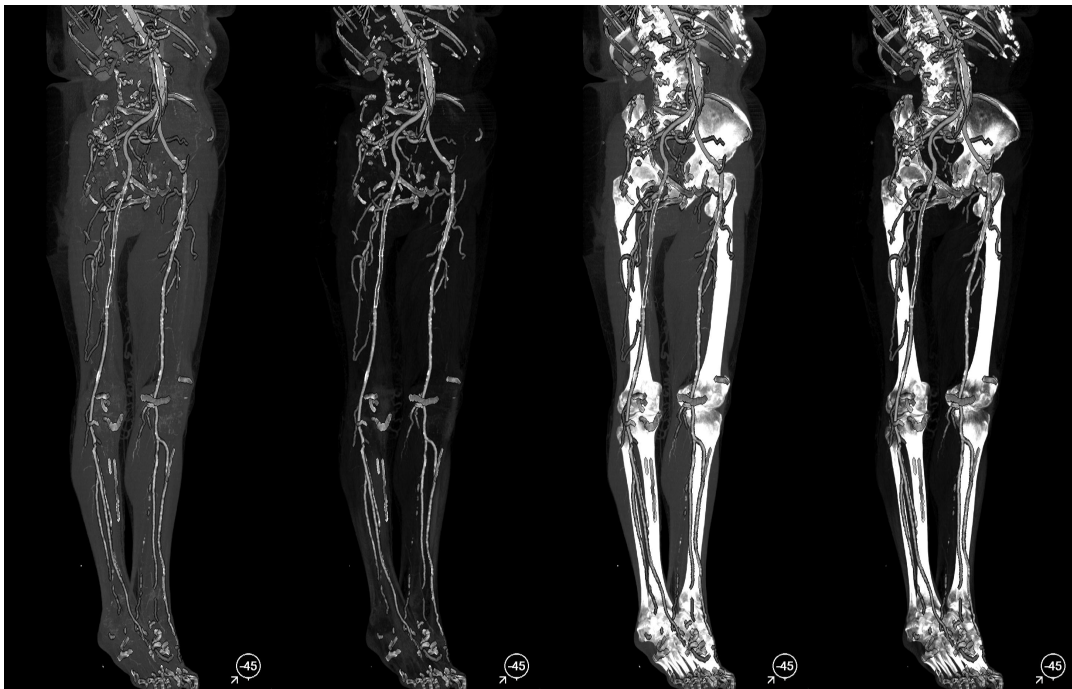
Result of focus and context rendering of a human CTA data-set. In all images the whole detected vessel tree is rendered. In the first two images bone is removed. Furthermore, the first and the third image use MIP whereas the second and the fourth image use MIDA. It is noteworthy that those contexts were rendered utilizing the described polygon rasterization, because of orthogonal projection. (Images created using the AngioVis Toolbox)*
